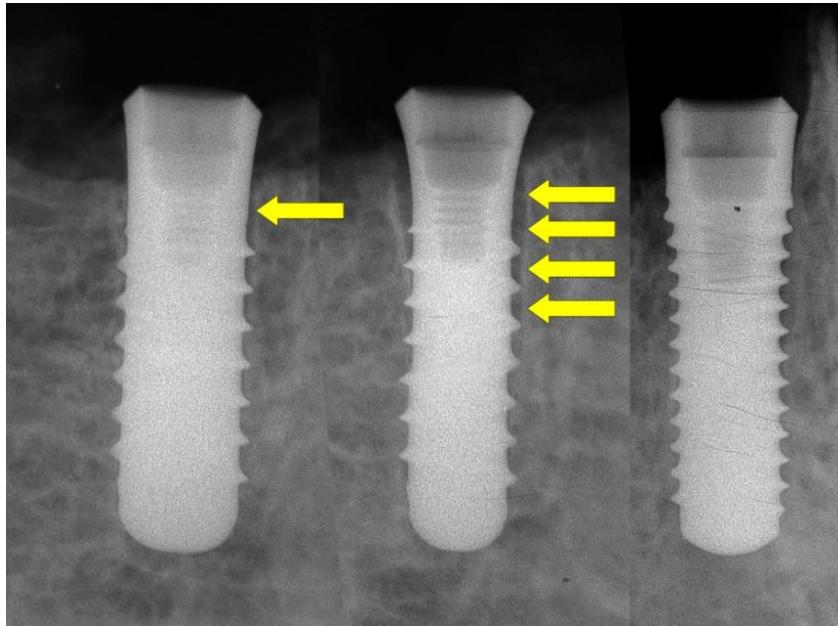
The primary stability of implants is influenced by many parameters such as implant design. When an implant is placed into a fresh extraction socket, the shape of the implant has a ruling effect on the measurements, because there is always a 3-dimensional bone defect, “jumping distance”, around the implants. In this example, the radiographic images of Ø 4.8 mm implant (left), Ø 4.1 mm solid screw (middle) and a TE (right) Straumann® implants clearly demonstrate that, an implant resembling the 3-dimensional shape of an extraction socket may potentially have “contact” at the collar region (TE implant), whereas a conventional implant may have little or no contact with bone. In the event an implant has contact with cortical bone, its insertion torque will increase.
